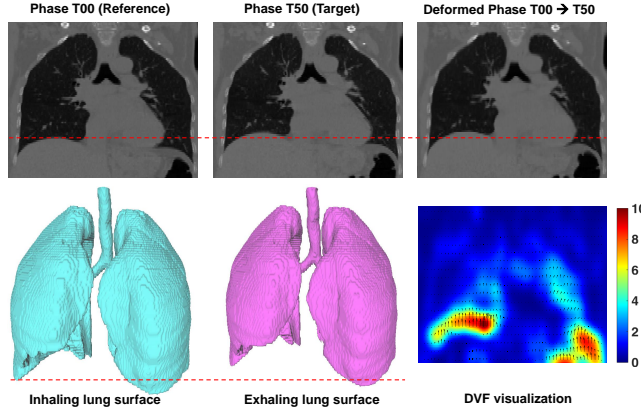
The deformed images and motions of the 4D clinical CT at phase T00 (end-inspiration) and phase T50 (end-expiration) from coronal views.
